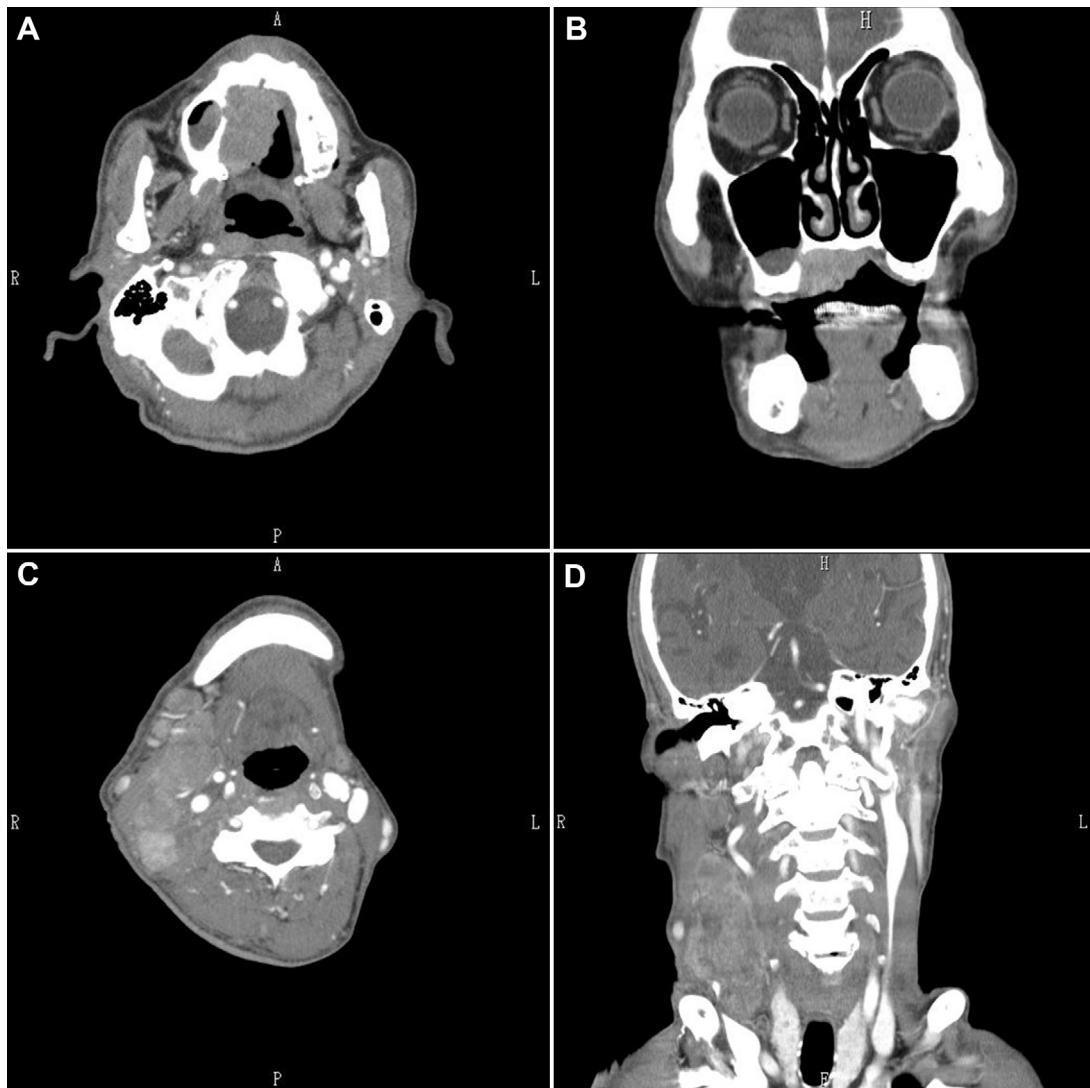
Enhanced CT. The right maxilla shows a mass with bone destruction (A: axial view, B: coronal view). Multiple enlarged lymph nodes are apparent, and show formation of a giant mass (C: axial view, D: coronal view).
